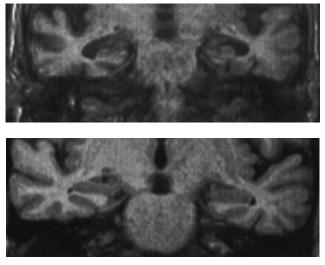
Coronal magnetic resonance imaging slices of patients with Alzheimer disease (AD) and dementia with Lewy bodies (DLB). Note severe atrophy of hippocampus and medial temporal lobe structures bilaterally in subject with AD. In contrast, the appearance of the medial temporal lobe in the subject with DLB is normal for age.
